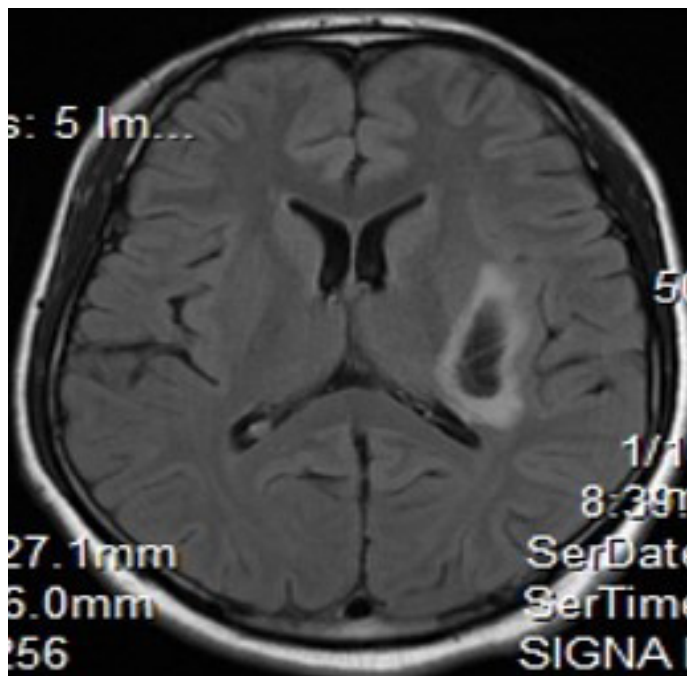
Axial T2 FLAIR MRI image showing Left putaminal acute haematoma with surrounding oedema impinging upon posterior aspect of posterior limb of left Internal capsule.
